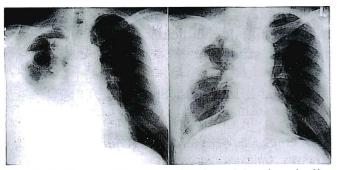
An X-ray of the chest showing right pleural effusion in August 1994 (left) and right pleural thickening with many nodules in the lung in May 1997 (right).
